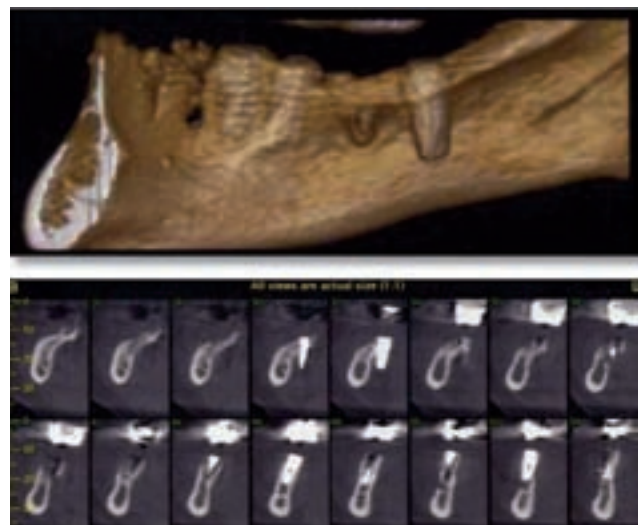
Implant failure due to extra-alveolar position after the implant was placed by an inexperienced clinician without the use of a preliminary CT scan, which could have shown the severe anatomic concavity on the mandible.
